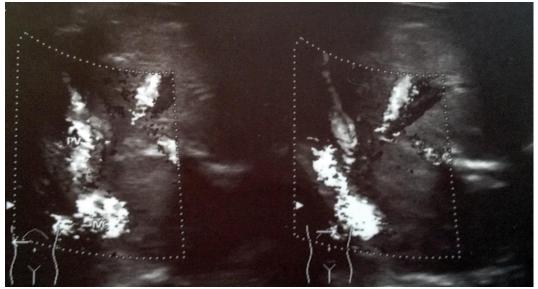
Patient B. U/S with Doppler imaging showing portosystemic shunt.
